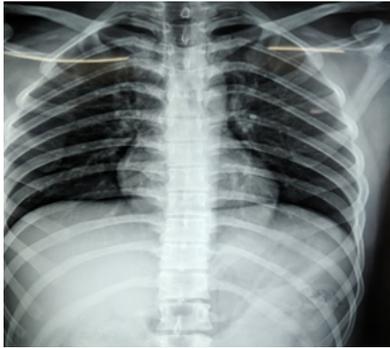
X-ray Chest -Normal
